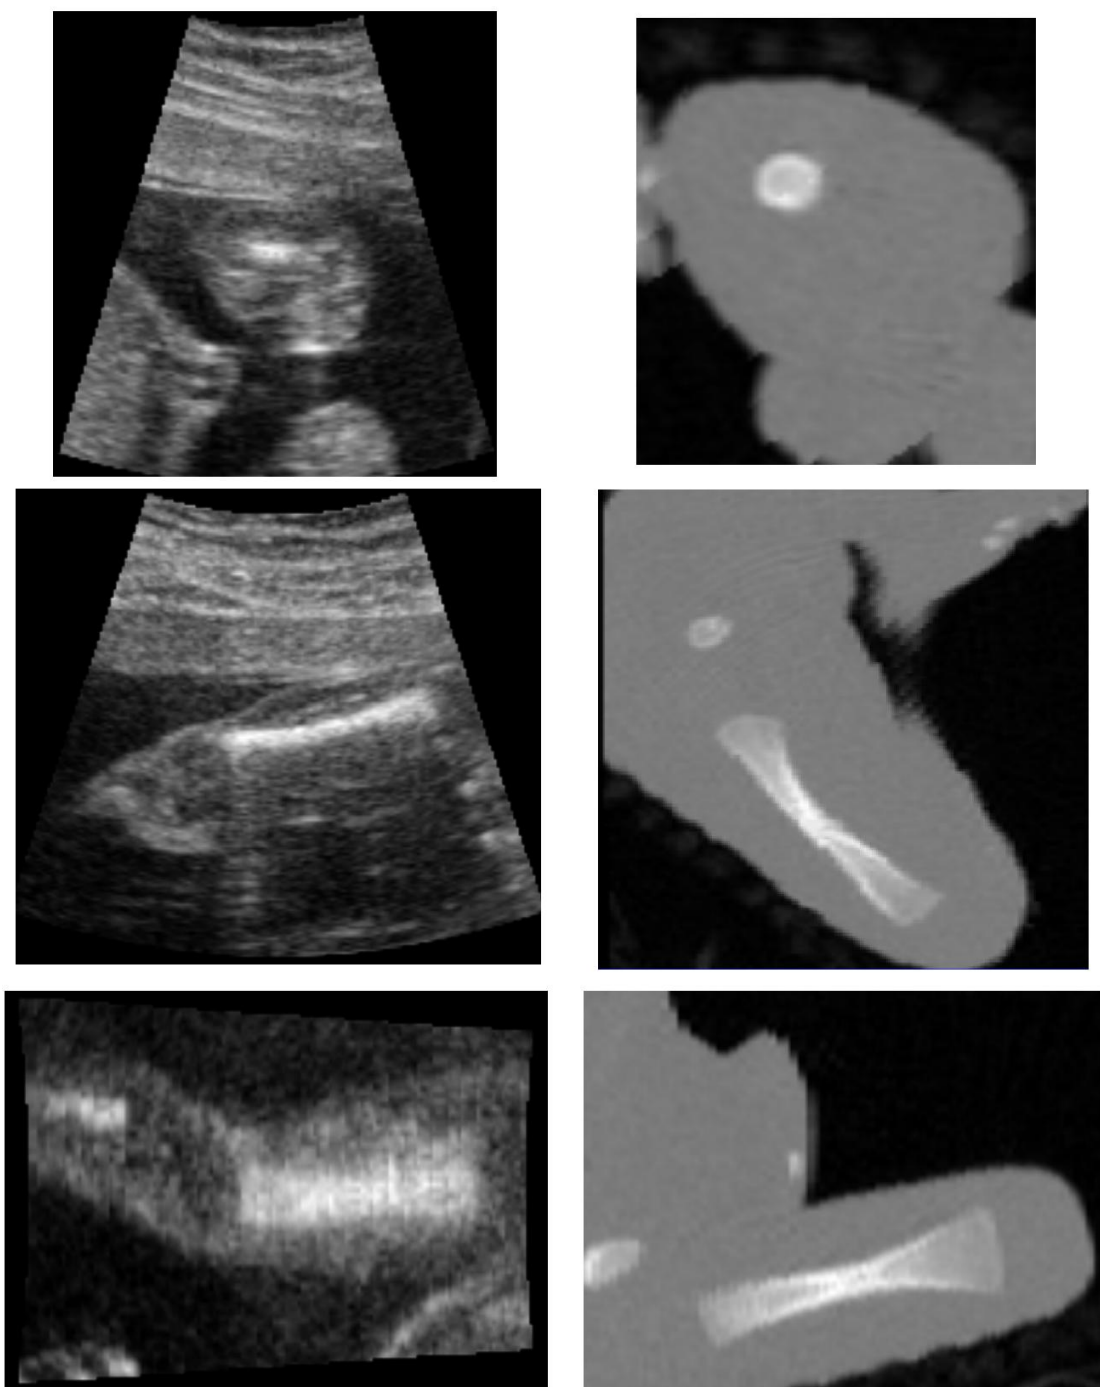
Ultrasound vs. CT of the femur. Axial (Top row), longitudinal (middle row), and coronal (bottom row) of a 3D ultrasound scan of the fetal femur (left column) and its CT scan (right column)
